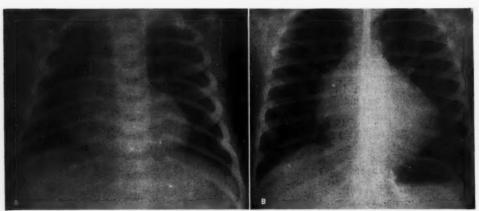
A. Case 1. Roentgenogram at ages 2 weeks shows a prominent right atrium and an inconspicuous main pulmonary artery from the onset. B. Case 1. Age 5 years. This anteroposterior film shows an enlarged cardiac silhouette with a globular configuration, a narrow pedicle, and slightly decreased vascularity of the peripheral lung fields.
